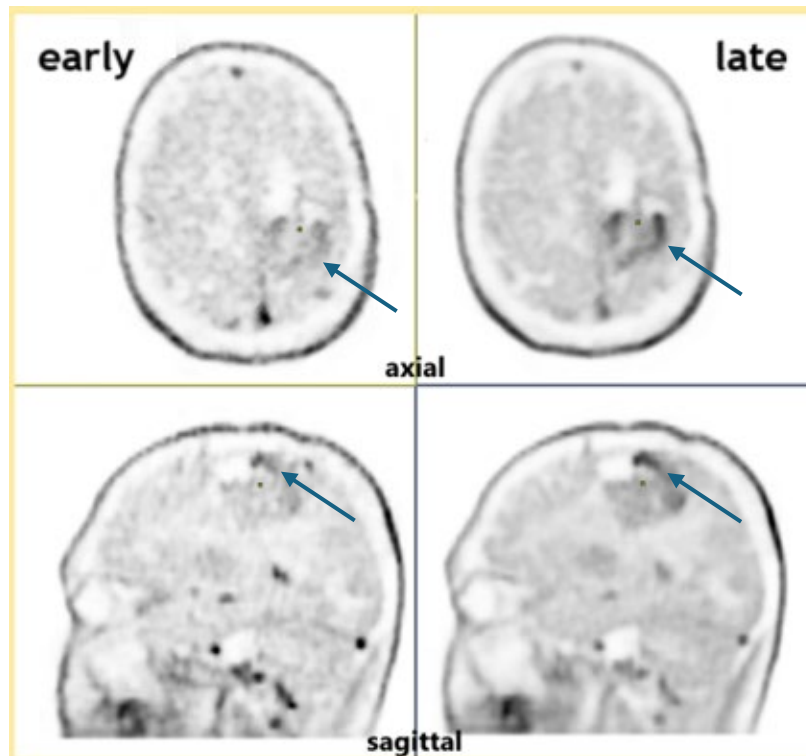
Visual comparison of tracer accumulation and distribution in ^{18}F -FET PET/CT in two-time intervals on scans of a 56-year-old male patient with astrocytoma WHO grade 4 on axial and sagittal planes. Visually, a more intense tracer accumulation in areas of interest (blue arrows) is determined over time. The intensity of the blood pool at the late stage decreases naturally, which is related to the molecular mechanism of amino acid uptake by LAT1.
